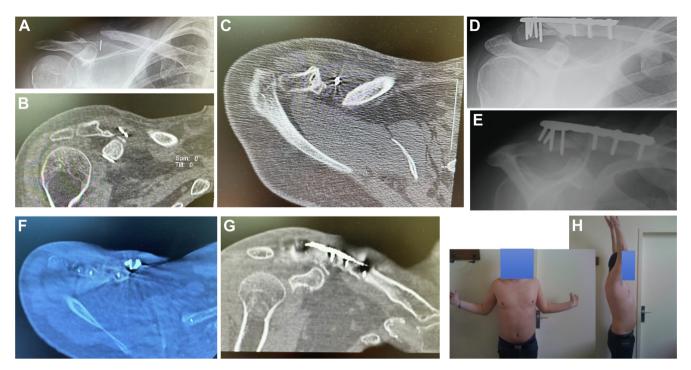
(A) Failed primary treatment of nonunion (endo button and iliac crest) (B, C) with 2.9 cm of bone loss and *C. acnes* sepsis in a 30-year-old patient (case 3). (D) First stage of Masquelet technique (removal of material, cement, and lateral superior plate with locking screws); (E) Second stage of Masquelet with iliac cancellous bone graft without (F, G) CT scan showing healing fracture at three months with a satisfactory clinical result (H).
